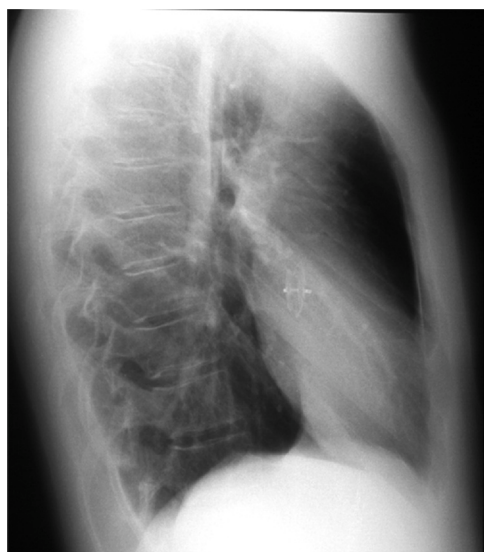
Lateral chest X-ray showing an Amplatzer PFO device in position. The smaller disc is in the left atrium, and the larger disc is in the right atrium.
